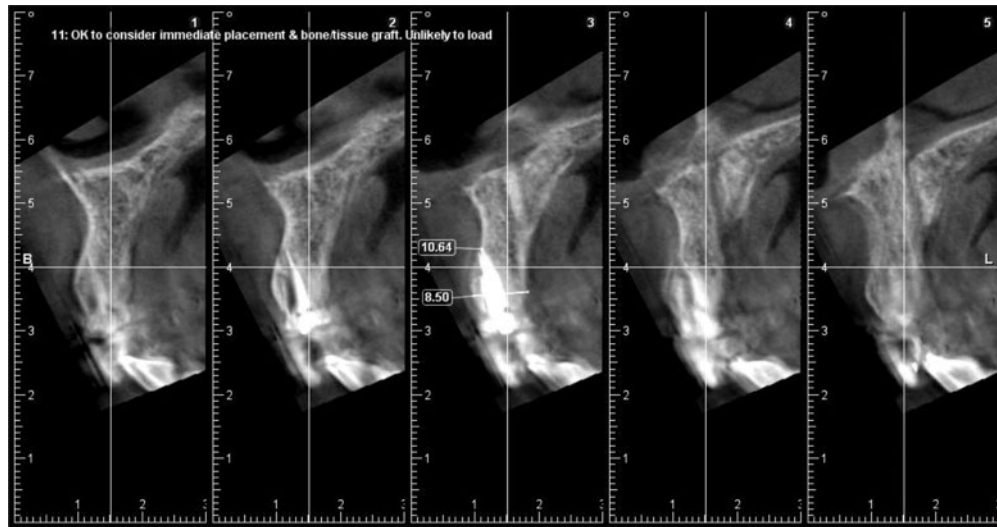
(B) Preoperative cross-sectional views from CBCT indicate that number 8 is facially canted. There is adequate palatal and apical bone for preparation of the osteotomy at the time of extraction.
